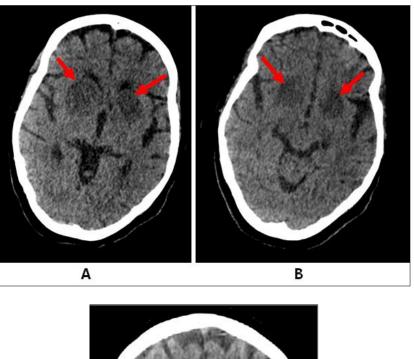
Cerebral CT scan without contrast injection in axial (A and B) and coronal (C) sections, showing bilateral, symmetrical lenticulo-caudate hypodensities with no mass effect on medial structures and no sign of cerebral involvement.
